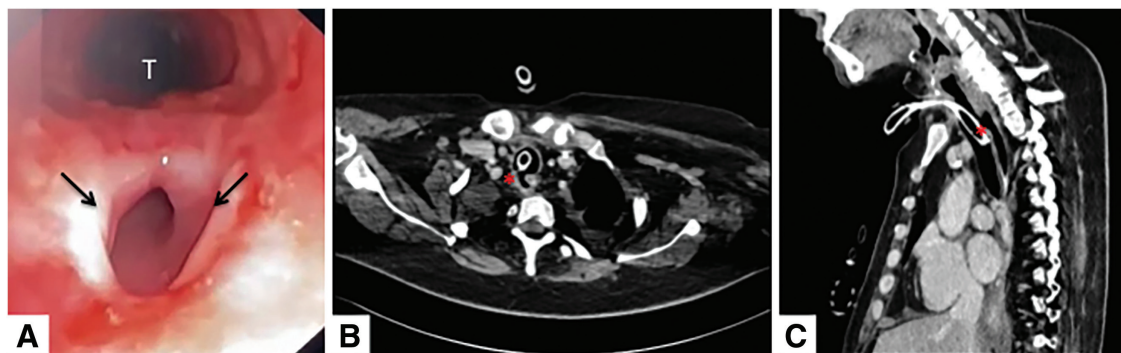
(A) Endoscopic visualization of the TEF (black arrows) from the trachea using flexible bronchoscopy. (B and C) Axial and sagittal chest computed tomography scans showing the TEF (red asterisk) at the level of the thoracic inlet. TEF: tracheoesophageal fistula; T: trachea
